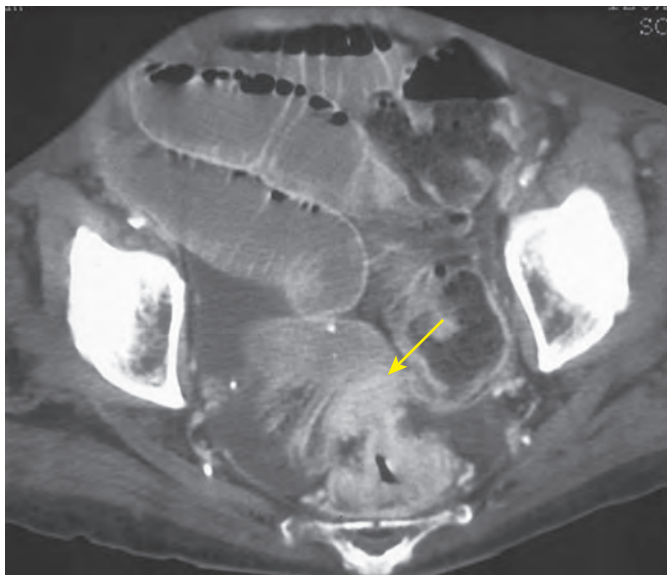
Transition zone with mass demonstrated at CT. Axial CT image through pelvis shows a dilated ileum. There is invasion of the distal ileum by a carcinoma (arrow) of the rectosigmoid junction.
